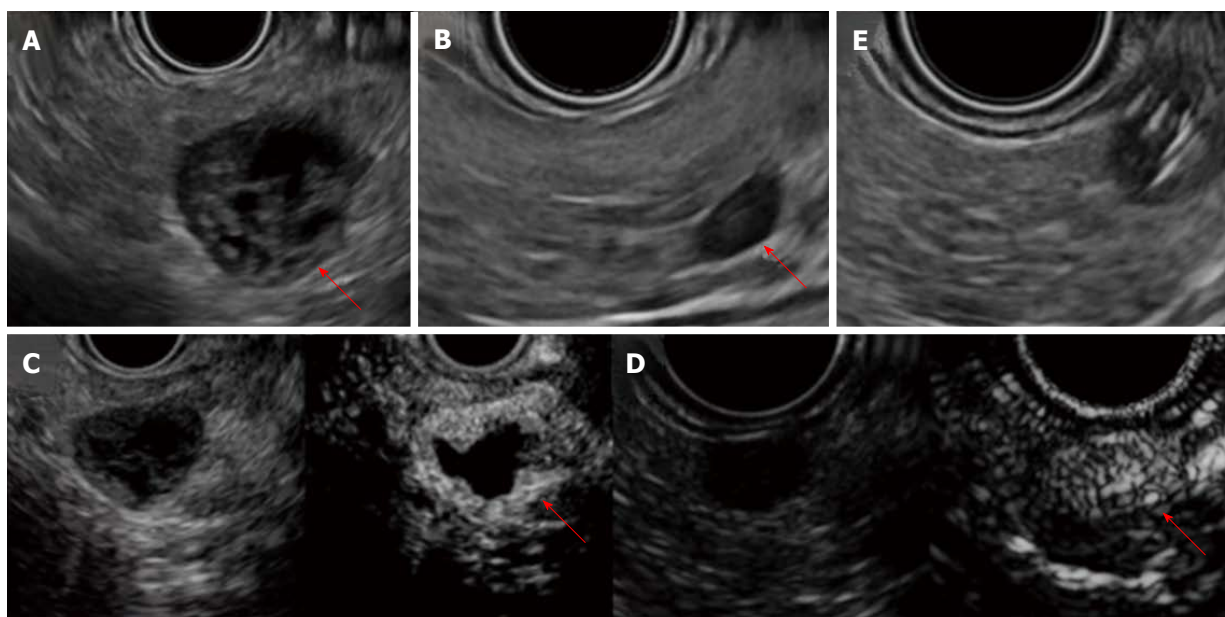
Findings from EUS and CH-EUS. A: The lesion in the pancreatic tail shows a hypoechoic peripheral rim and nodule. Inside the cyst, no echoic fluid or solid structure is detected; B: A new, 7-mm microtumor in the pancreatic body, apparent only on EUS; C: The rim of the cystic lesion and nodule appear enhanced immediately after injection of contrast medium on CH-EUS; D: The 7-mm microtumor is similarly enhanced on CH-EUS; E: Endoscopic ultrasound-fine needle aspiration to biopsy the 7-mm microtumor. CH-EUS: Contrast-enhanced harmonic-endoscopic ultrasound; EUS: Endoscopic ultrasound.
